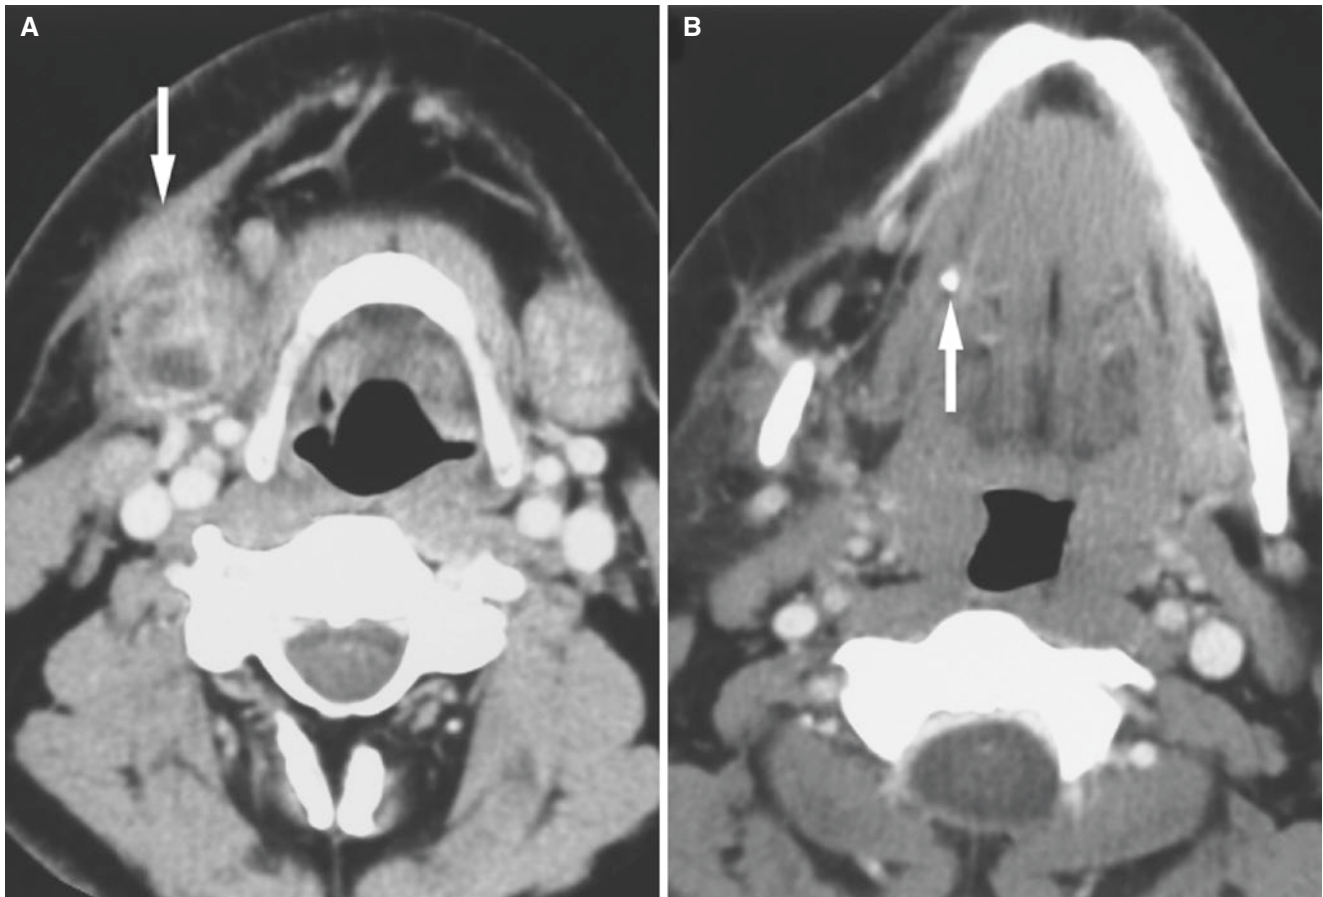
Submandibular gland multilocular abscess due to stone in Wharton's duct; 69-year-old male with intermittent submandibular swelling and tenderness. (A) Axial post-contrast CT shows enlarged
